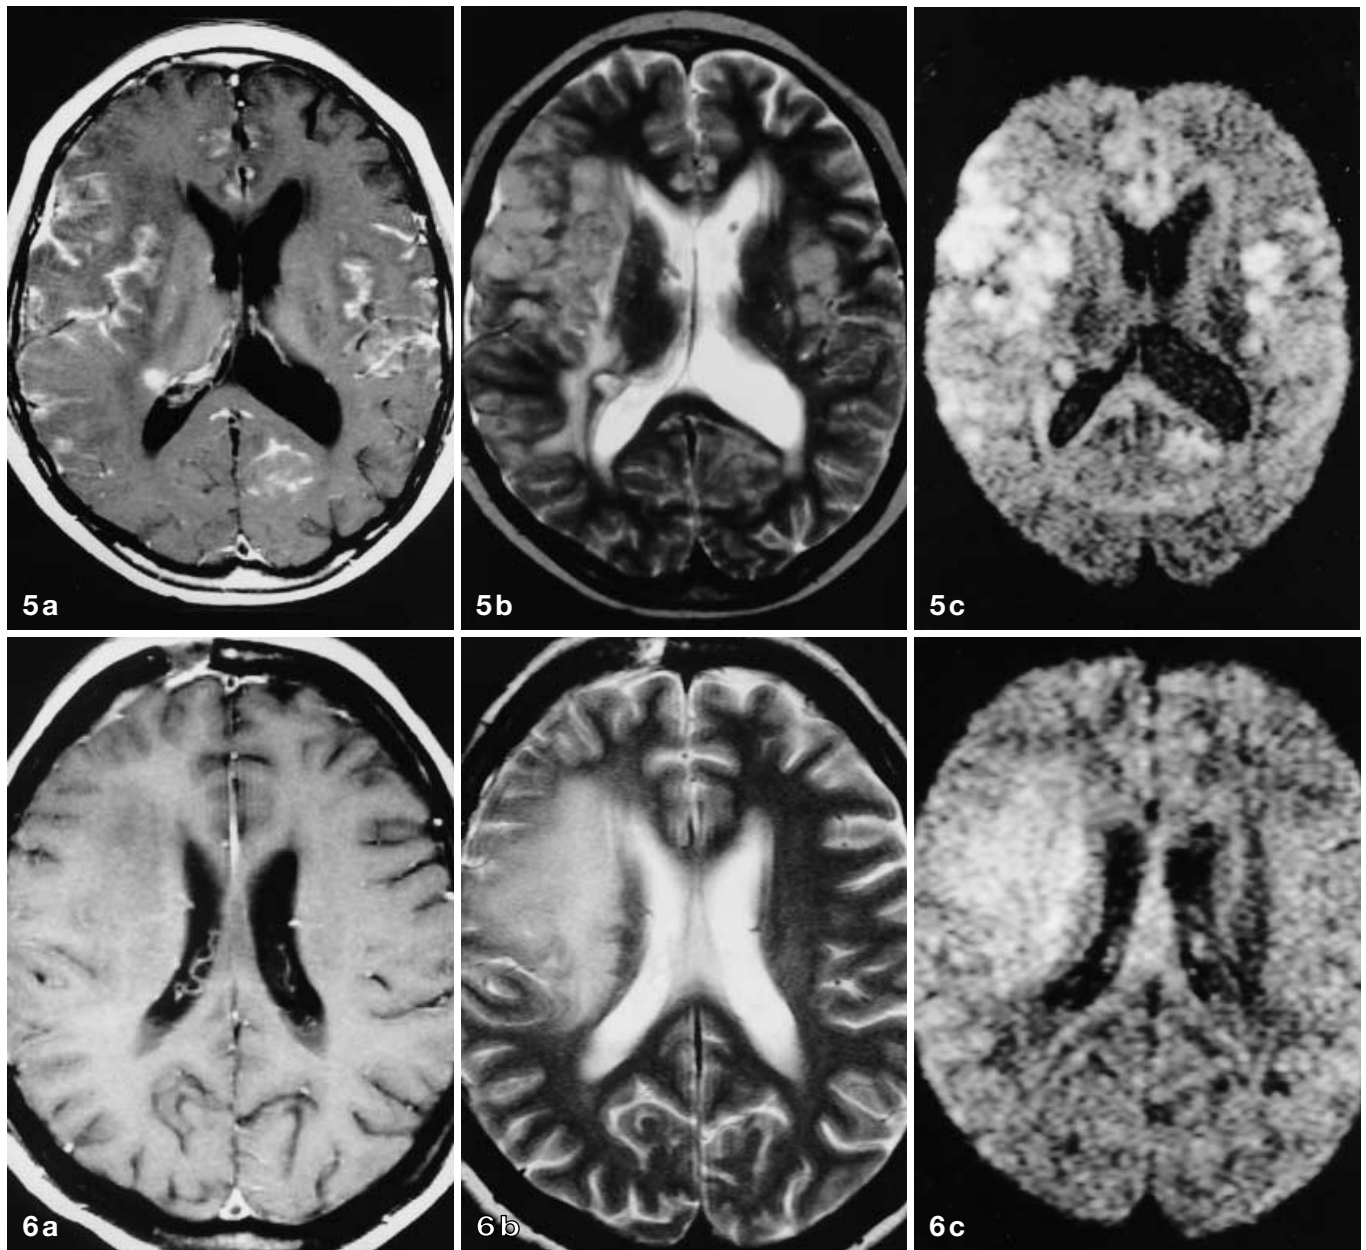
Type 2. A 16-year-old boy with disseminated medulloblastoma. a Postcontrast T1-weighted SE image (TR/TE: 460/12 ms) shows disseminated lesions at the right frontal surface, in the cerebral sulci, and in the bilateral sylvian fissures. b Disseminated lesions are seen as hyperintense areas, but each lesion is not so clearly distinguished from the surrounding cerebrospinal fluid and the cerebral cortex on T2-weighted turbo-SE image (TR/TE: 3000/102 ms). c Diffusion-weighted echo-planar imaging with a b value of 1200 s/mm^2 shows these lesions more conspicuously as markedly hyperintense areas
